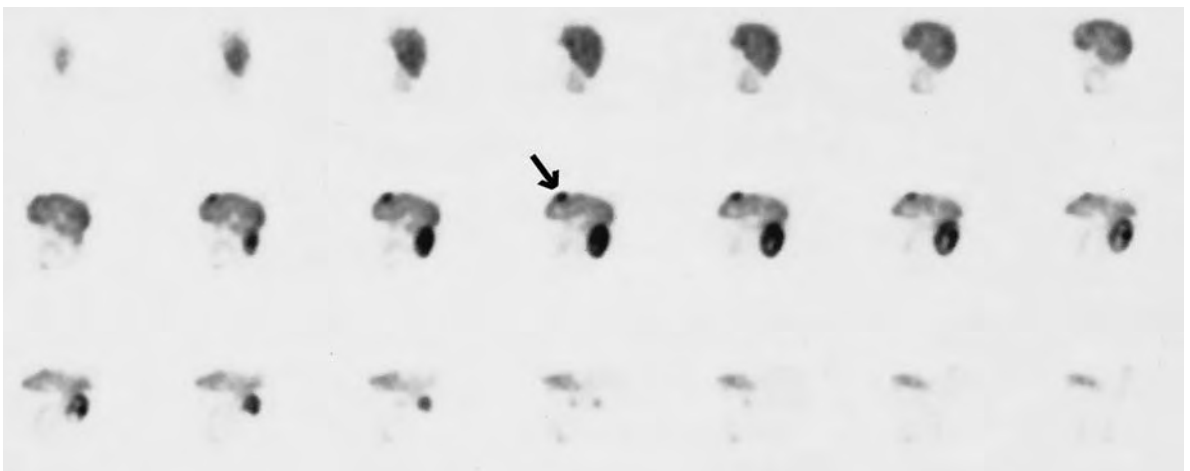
$^{99\text{m}}\text{Tc}$ -Depreotide (P829) scintigraphy indicates in a patient with pancreatic adenocarcinoma and a larger liver metastasis (arrow) at 90 min post injection of 150 MBq radioligand (SPECT: sagittal reconstruction)
